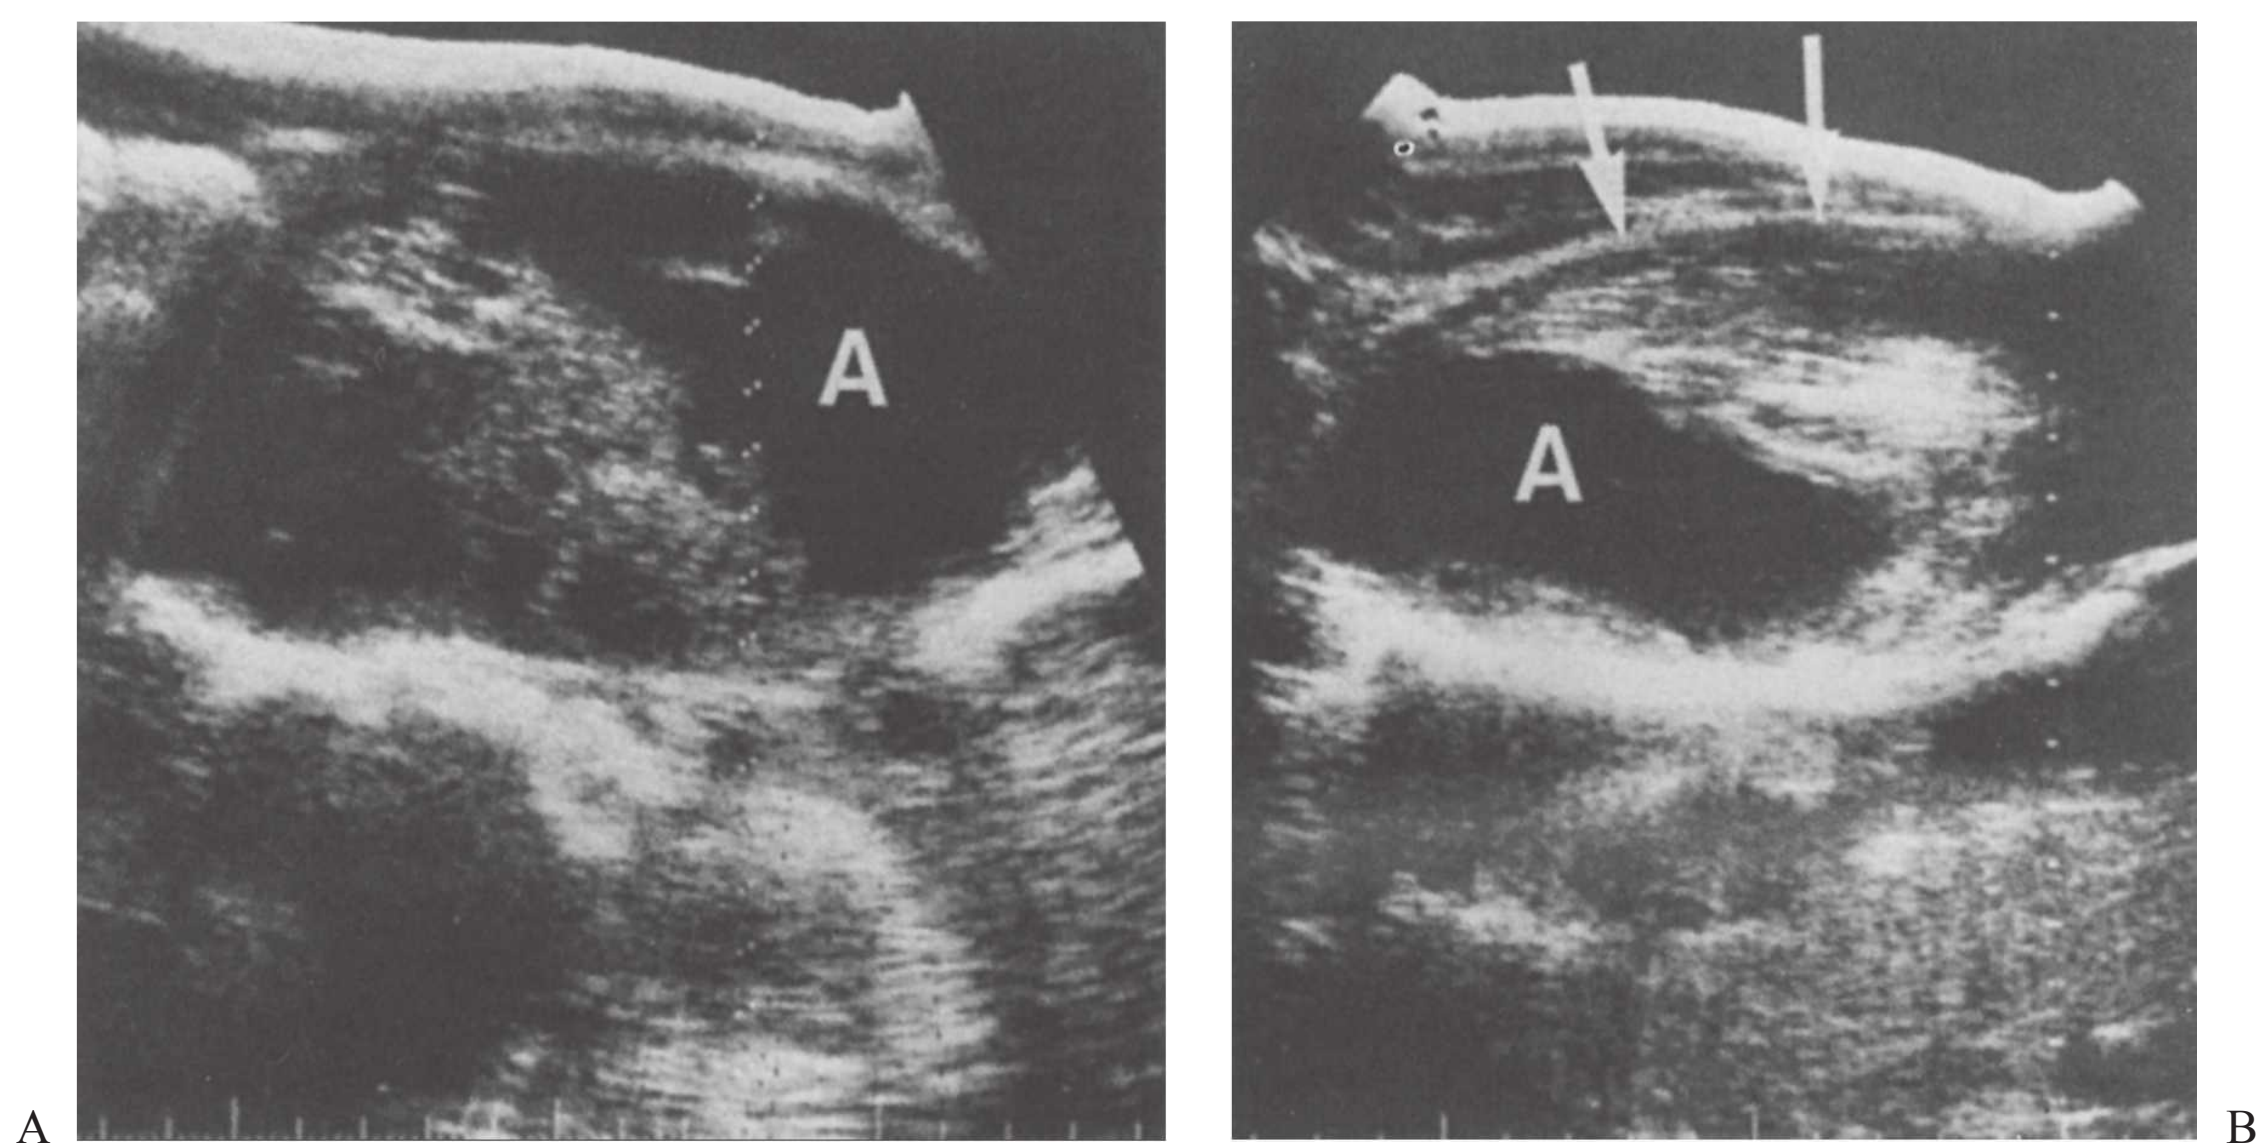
A: Longitudinal ultrasonogram down the right paravertebral region, demonstrating a huge complex mass with a large irregular fluid component, labeled A. B: Marked enlargement of the psoas major muscle (arrows) with a large contained fluid collection, labeled A. (From Andriole VT. The clinician's viewpoint. *Clin Diagn Ultrasound*. 1982;11:1, with permission.)
